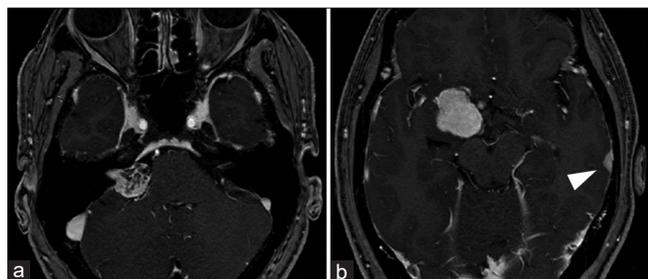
Preoperative imaging of the patient. MRI revealed a right CPA tumor suspected to be a vestibular schwannoma (a), a right sphenoid ridge extra-axial tumor suspected to be meningioma (b), and a left temporal extra-axial tumor also suspected to be a meningioma (b, arrow head). MRI: magnetic resonance imaging, CPA: cerebellopontine angle.
